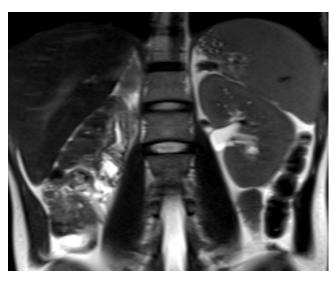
Coronal T2 weighted MR image shows the right renal agenesis, with bowel loops in the right renal fossa. The left kidney has a normal appearance.
